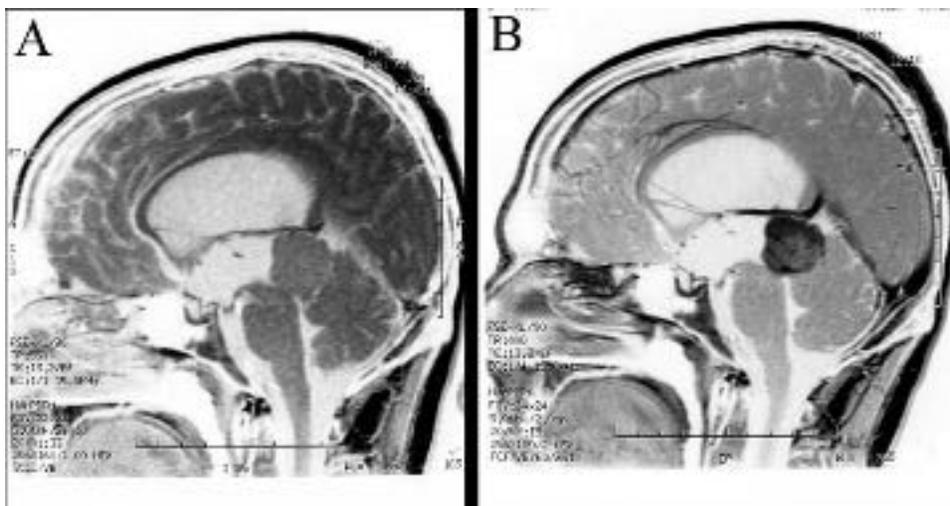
Magnetic resonance imaging (MRI) features of velum interpositum meningiomas. (A) Sagittal T1 MRI demonstrates an extraaxial posterior third ventricle/pineal region tumor. There is local mass effect, with midbrain compression and upward displacement of the deep cerebral venous system. (B) Strong enhancement postadministration of gadolinium is apparent.
